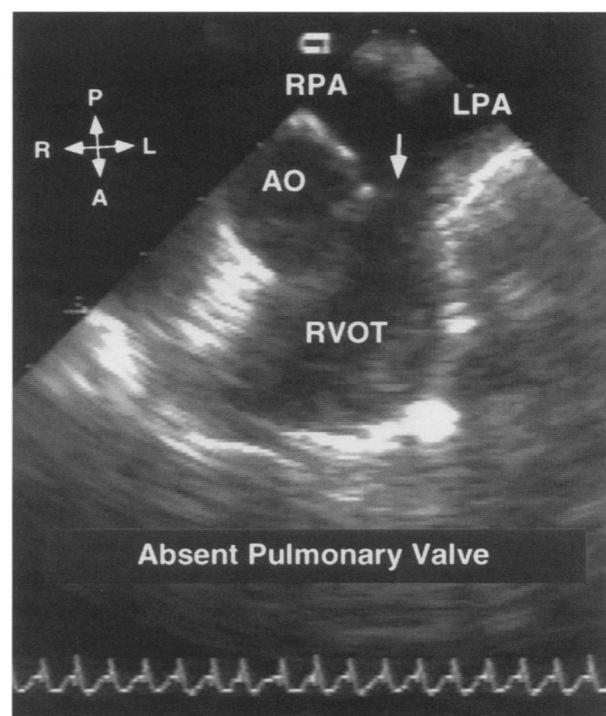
Transverse basal short-axis view in a patient with absent pulmonary valve syndrome, showing a narrow right ventricular outflow tract with dilated branch pulmonary arteries. Rudimentary valve tissue is also noted (arrow). This plane is ideal for pre- and postoperative Doppler evaluation of the pulmonary outflow tract and pulmonary arteries.
